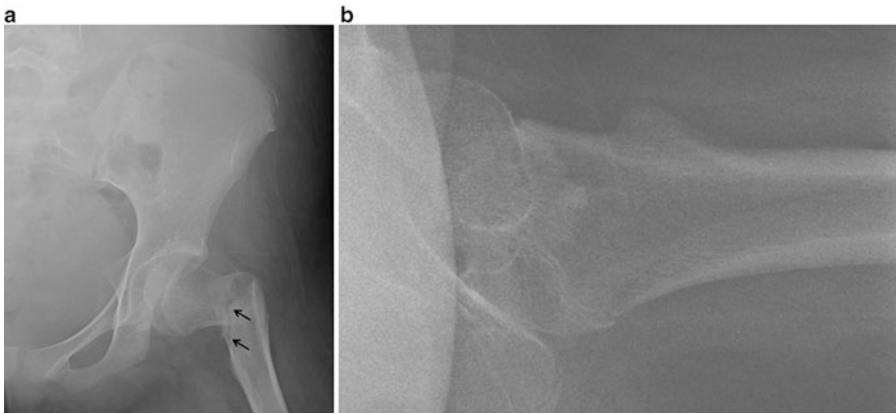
(a) AP radiograph of the left hip in a 12-year-old female demonstrates a fracture through the cervicotrochanteric portion of the femoral neck. (b) Lateral
